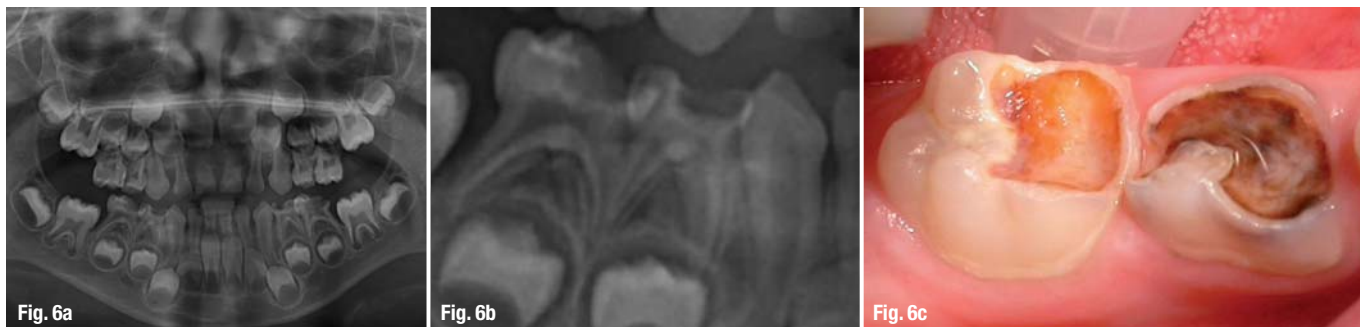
a-c Female patient, 5.2 years old. Deep caries on molar teeth. Panoramic view (a). X-ray control (b) and occlusal vision (c).
